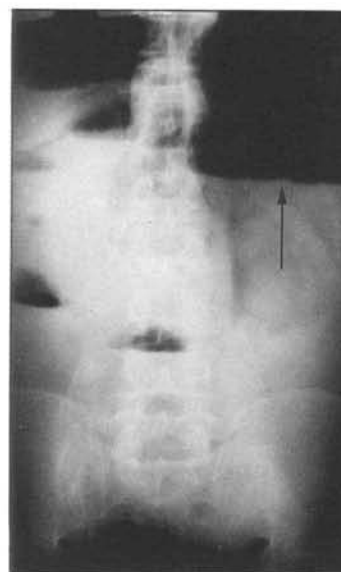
Abdominal roentgenogram obtained in orthostasis. Upper left abdominal quadrant cecum is suspected
